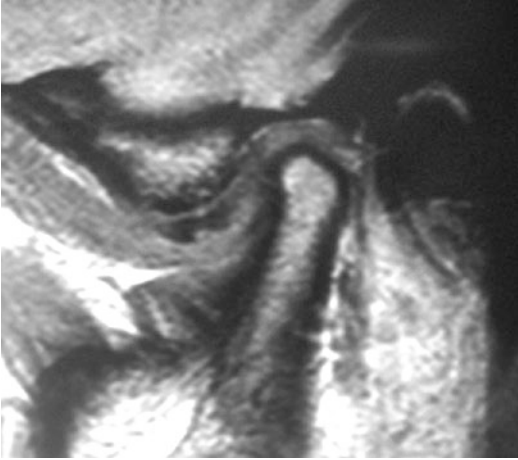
Category 2, Minor TMJ Changes—MRI showing mildly displaced disc which reduces on opening. Condyle is normal. Future studies may look at whether TMJ arthrocentesis/arthroscopy significantly reduce the treatment time span compared to conservative measures alone in category 2 patients
